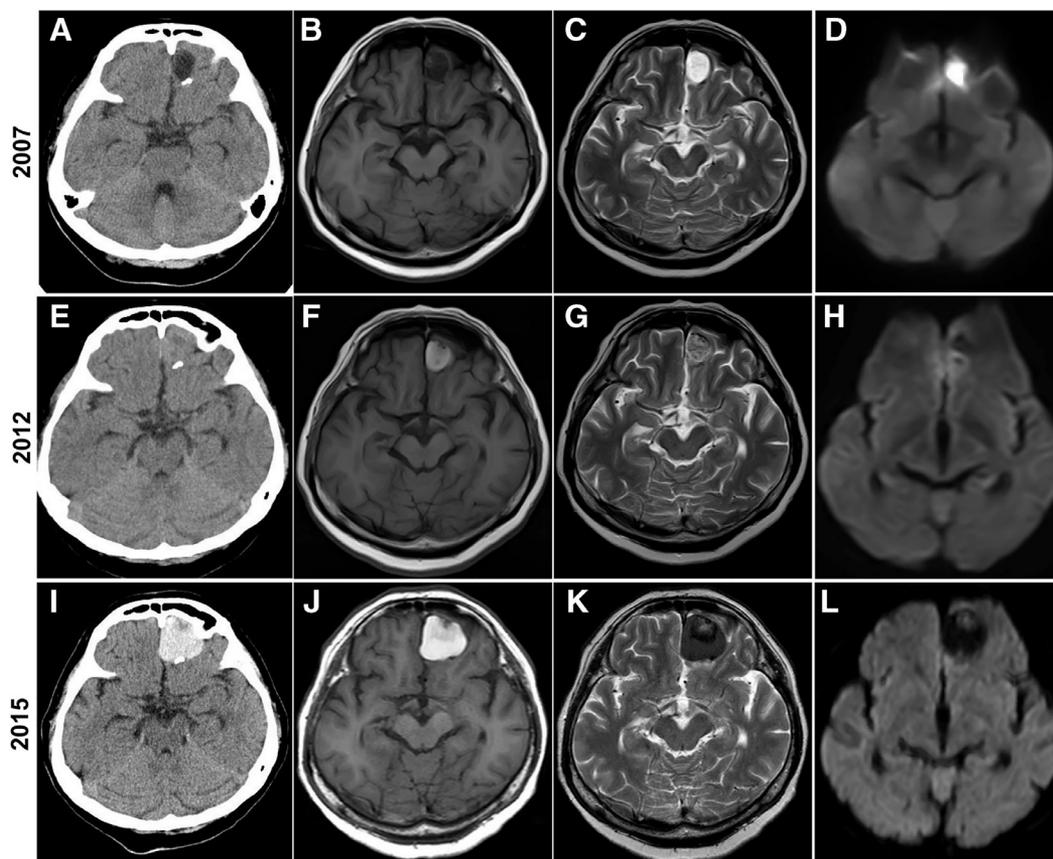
Initial and follow-up CT and MRI. May 2007: Homogeneously hypodense mass of 13 × 21 × 16 mm in the left frontal lobe with a focus of calcification on CT scan (A), low signal intensity on T1-weighted images (T1WI) (B), and high signal intensity on both T2-weighted images (T2WI) (C) and Diffusion-weighted imaging (DWI) (D). November 2012: Density change in the mass without significant size change on CT (E), high signal intensity on T1WI (F), and heterogeneously increased signal intensity on T2WI (G); indistinct on DWI (H). November 2015: Enlargement of the cyst with homogeneously high density on CT (I), T1WI with increased signal (J) compared to the previous image (F), low signal intensity on T2WI (K), and DWI (L).
